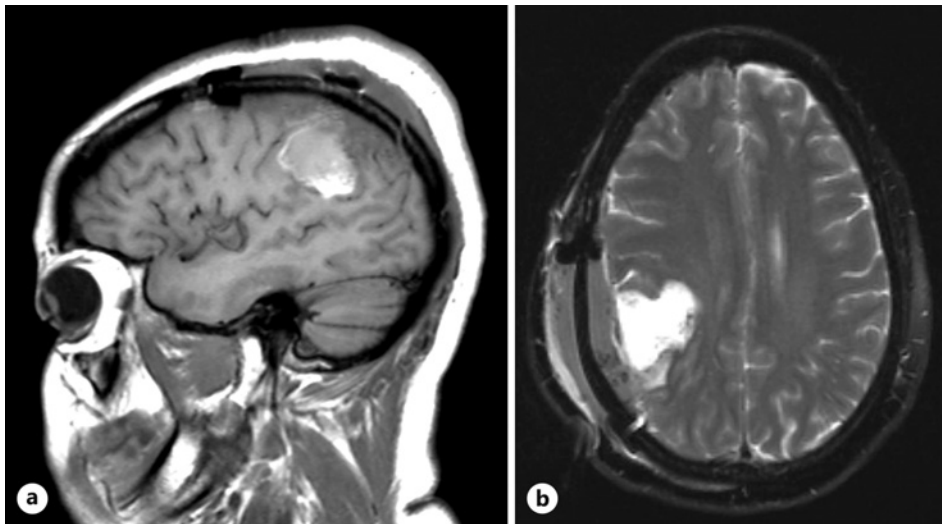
a, b Postoperative MRI demonstrates gross total resection of the right parietal mass with expected postoperative changes.
